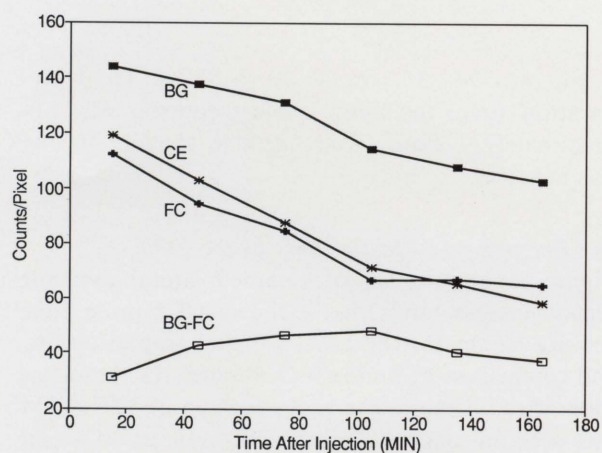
The 180 minute time activity curves of the 6 serial SPECT scans, for the basal ganglia (BG), frontal cortex (FC), and cerebellum (CE). The specific binding of  $^{123}\text{I}$ -IBZM in the basal ganglia was calculated as the difference between basal ganglia and frontal cortex (BG-FC). An equilibrium was seen from 60 to 120 minutes showing binding reversibility.
